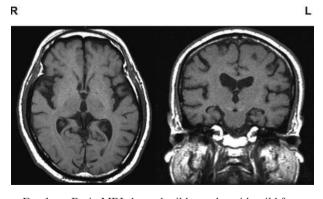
Brain MRI showed mild atrophy with mild frontotemporal atrophy. The MRI findings were not inconsistent with Alzheimer's disease.
